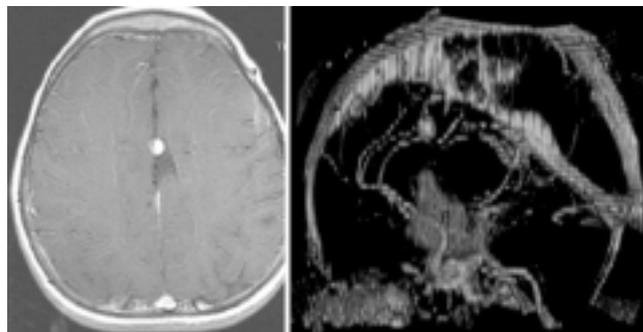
Axial MR image (*left*) and MR angiogram (*right*) demonstrating a partially thrombosed pericallosal artery aneurysm.
